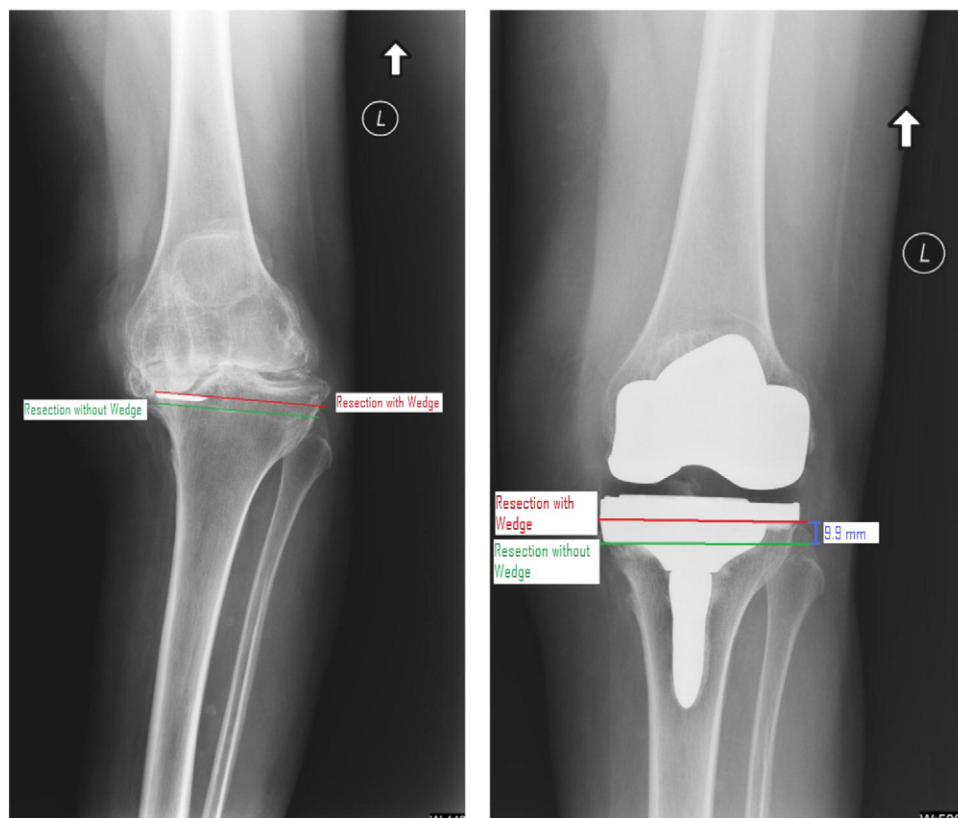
Preoperative and postoperative anteroposterior radiographs showing excellent alignment.
